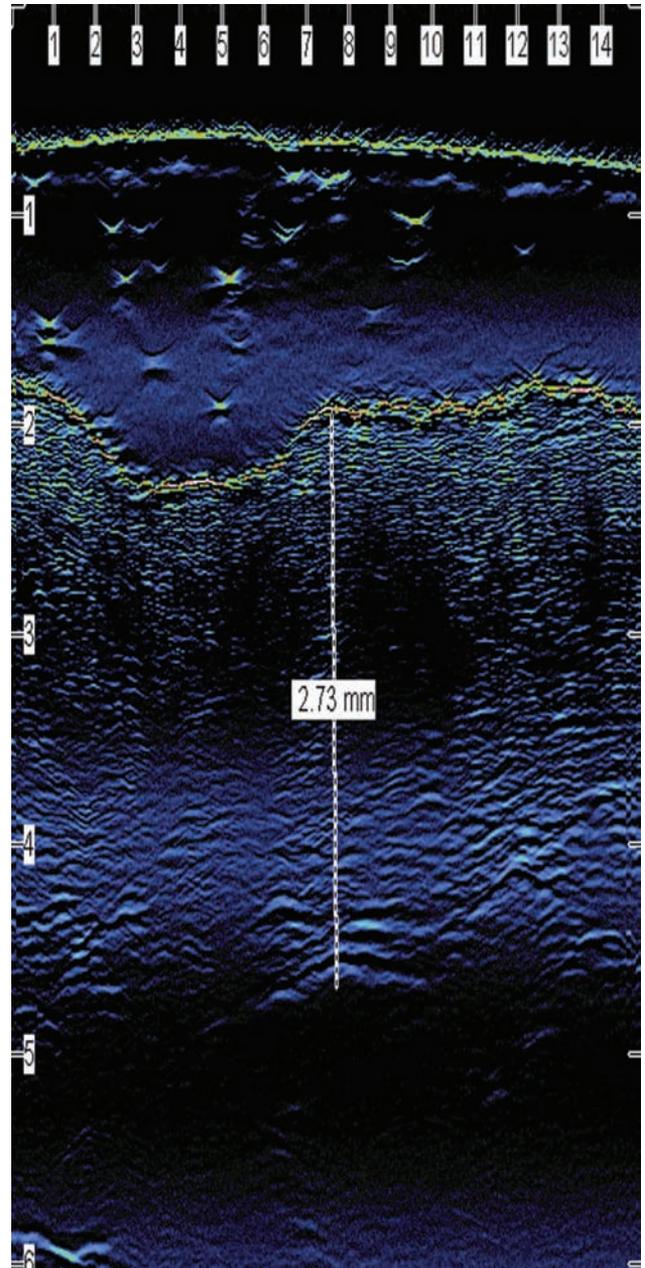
Ultrasound image of grafted scar.
